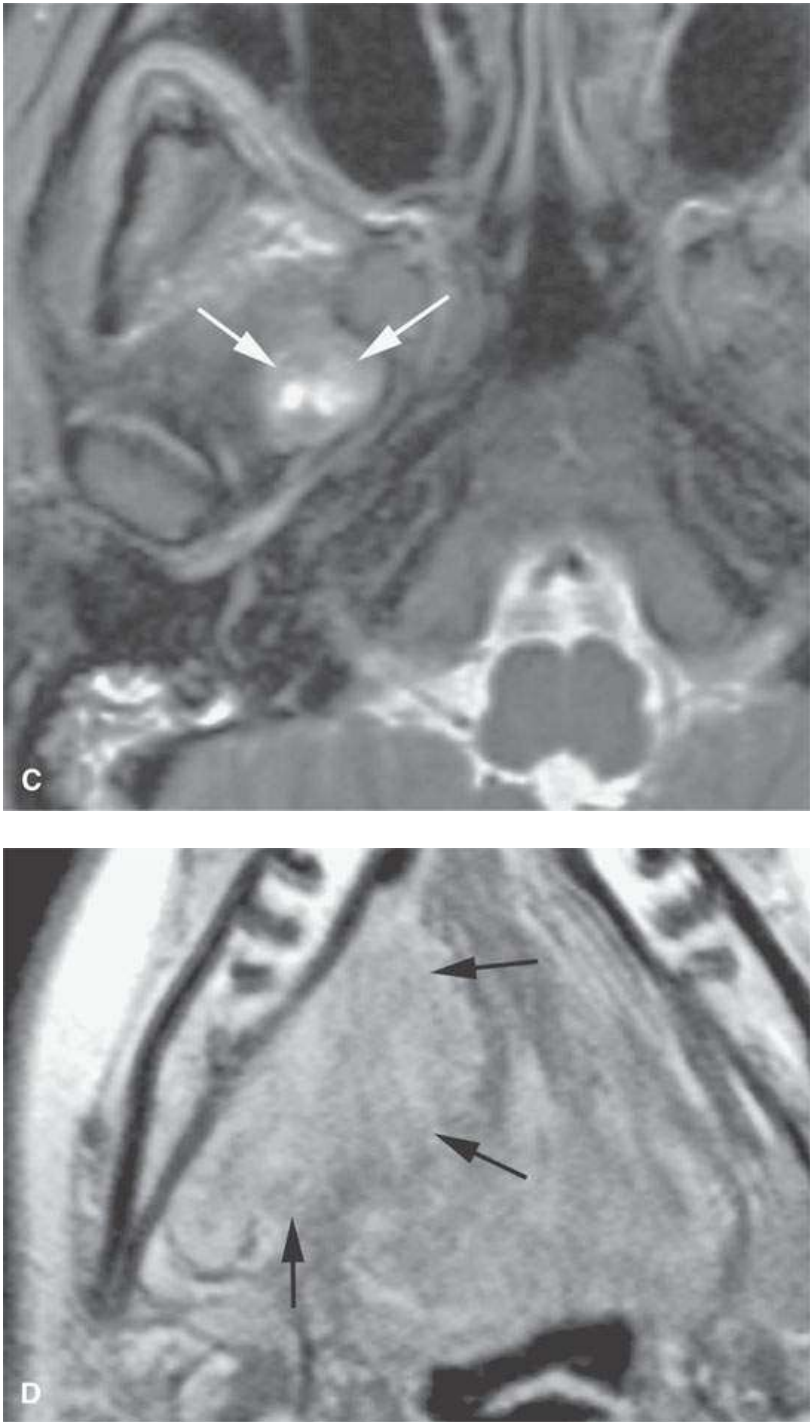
A young woman with facial pain and what was believed to be a transcranial meningioma based on outside prior imaging studies. This magnetic resonance imaging study showed a primary malignancy of the floor of the mouth with spread along the lingual nerve to V3 and then the trigeminal ganglion. It was believed to be a neurogenic sarcoma on the basis of the imaging but turned out to be a rhabdomyosarcoma of the floor of the mouth with perineural spread of tumor. The imaging findings dramatically altered the treatment plan. A: Contrast-enhanced T1-weighted (T1W) image shows tumor spreading along V3 (arrows) to its junction with the trigeminal nerve ganglion (arrowheads). B: Contrast-enhanced T1W image shows tumor spreading along the lingual nerve (arrows). C: T2-weighted image shows tumor spreading along V3 to the foramen ovale (arrows). D: Contrast-enhanced T1W image shows the tumor’s origin in the floor of the mouth (arrows).
